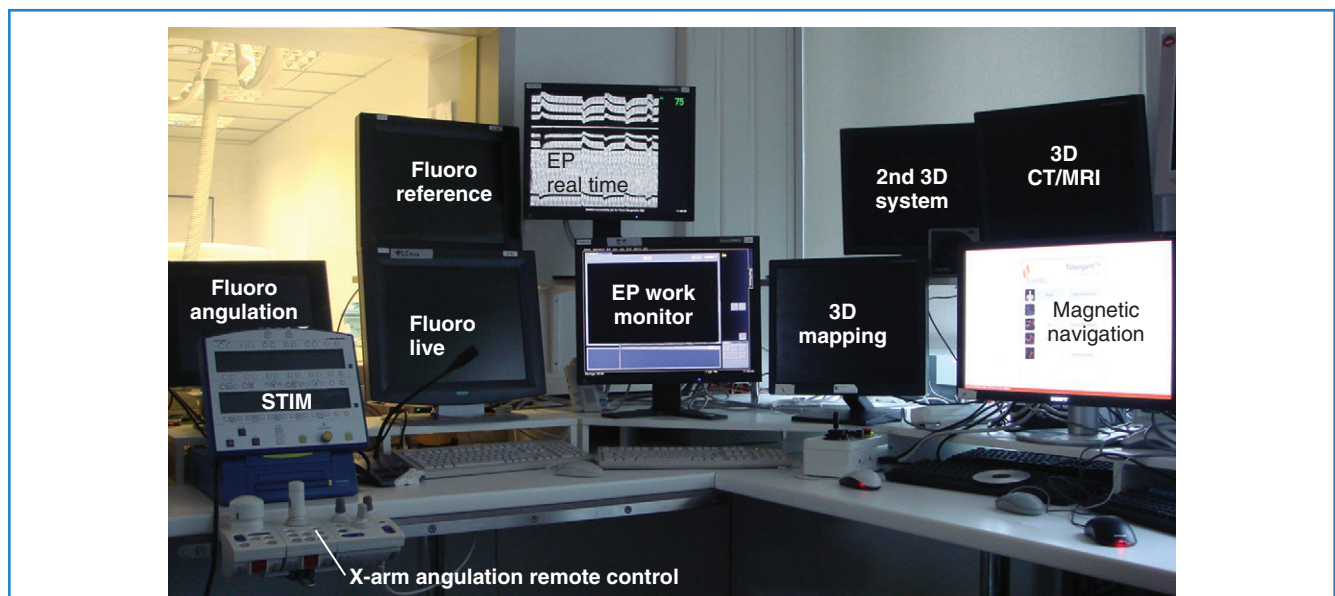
View of the control area of a catheter laboratory using remote control by magnetic navigation (at St. Georg Hospital, Hamburg, Germany). The monitors are arranged as in a cockpit, allowing a single operator to lead the investigation. *Fluoro*, Fluoroscopy system; *STIM*, cardiac stimulator; *EP*, electrophysiology recording system; *3D*, three-dimensional; *CT*, computed tomography; *MRI*, magnetic resonance imaging.
